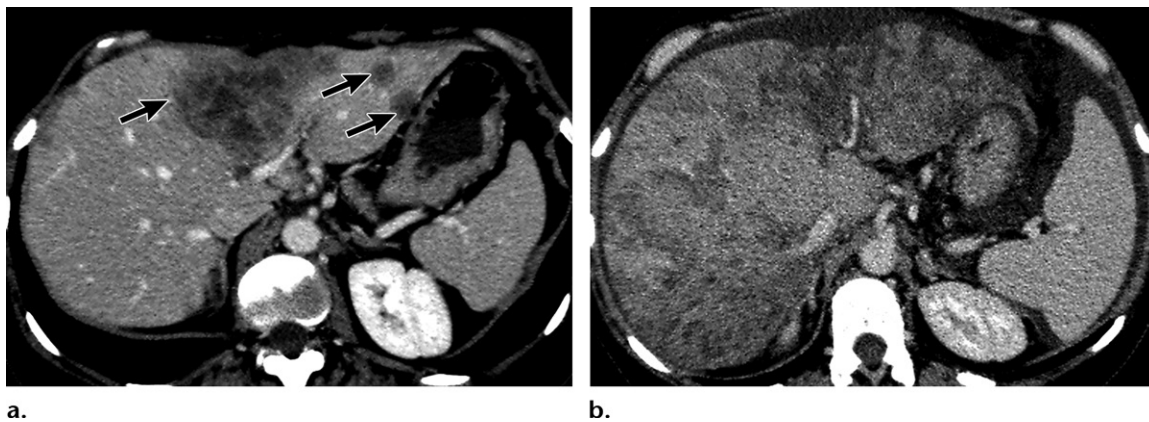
REILD in a 42-year-old woman with metastatic breast cancer. (a) Axial portal venous phase CT image shows liver metastases (arrows) in the left lobe. (b) Axial post-TARE follow-up CT image shows hepatomegaly, with marked parenchymal heterogeneity and ill-defined hypoattenuating areas in both lobes. Ascites and mild splenomegaly also are seen.
